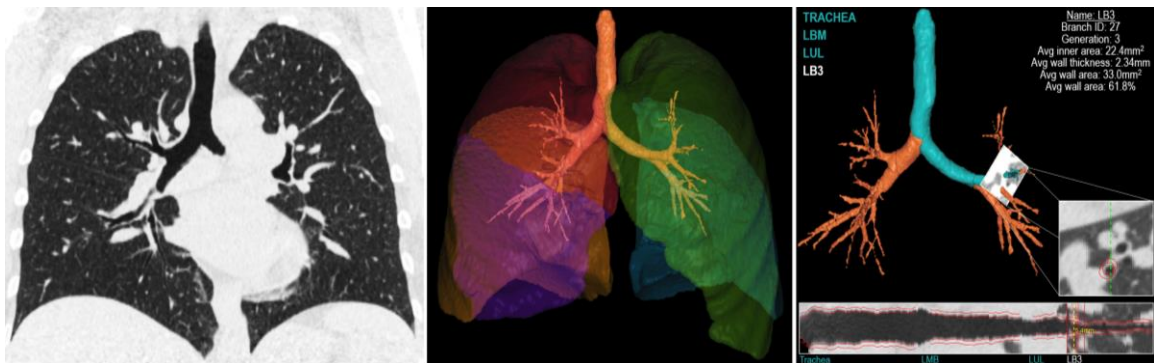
Three-dimensional quantitative CT of the lungs and airways in asthma. Coronal CT (left panel) and the corresponding three-dimensional rendering of the lung and airway tree using Pulmonary Workstation 2.0 (VIDA) (middle panel). The trachea, left
